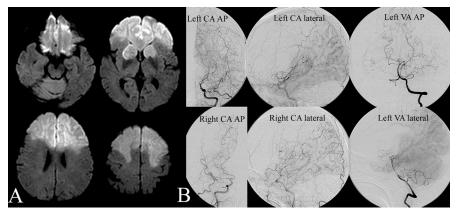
(A) Diffusion-weighted axial MRI shows an acute infarction involving the bilateral frontal lobes and anterior portions of the basal ganglia.
